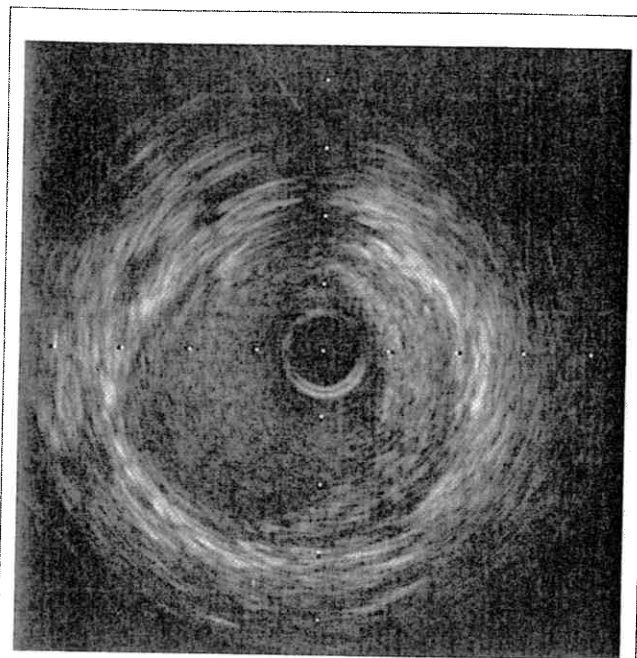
Intravascular Ultrasound in TCAD
